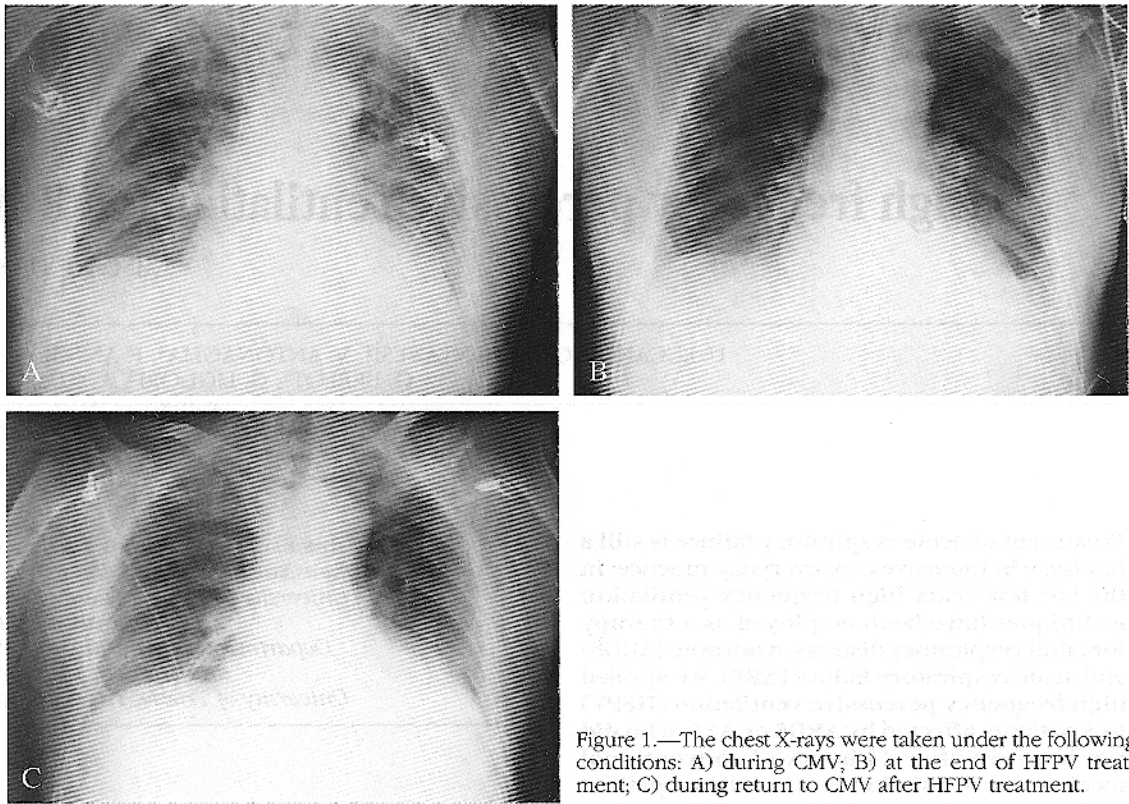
The chest X-rays were taken under the following conditions: A) during CMV; B) at the end of HFPV treatment; C) during return to CMV after HFPV treatment.
